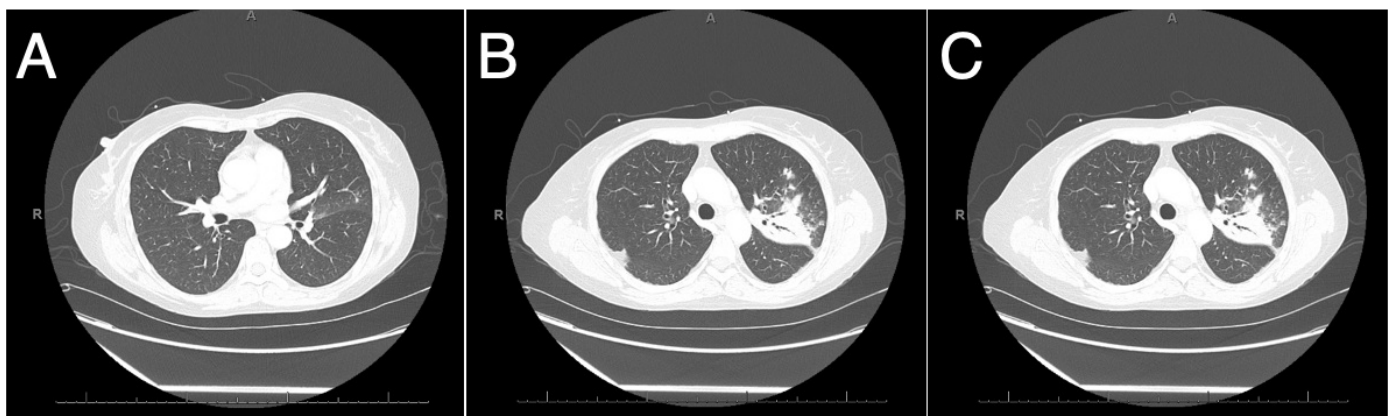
Coronal CT with contrast. A) Mildly prominent bilateral hilar and mediastinal lymph nodes, particularly in the subaortic region, up to 8 mm in short axis with prominent right retropectoralis lymph node measuring 1.1 cm as per radiologist report. B) Upper left lobe consolidation with necrotizing bronchopneumonia. Additional consolidation in the periphery of the right middle lobe associated with tree-in-bud/branching nodular density. Additional milder nodes were found throughout the right upper lobe. C) Extensive consolidation of the left upper lobe with central areas of lucency. Additional branching of macronodular opacities are noted.
